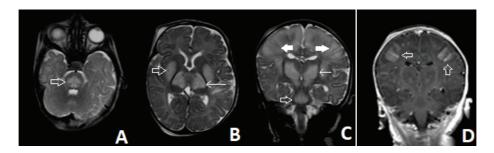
Brain Magnetic Resonance Images of Osmotic Demyelination Syndrome
